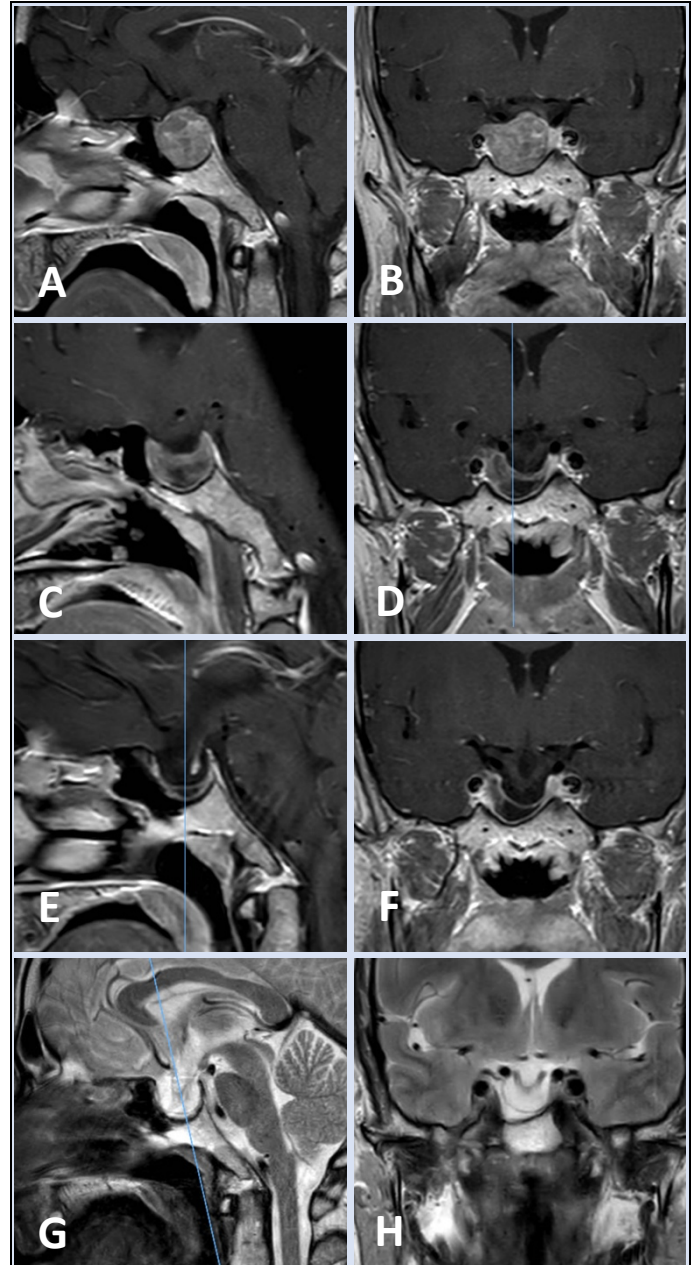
MRI of sellar region (sagittal and coronal): A and B, prior to medical management of prolactinoma; C and D, 8 months after the initiation of cabergoline treatment; E and F, 21 months after the initiation of cabergoline treatment; G and H, 4 years after the initiation of cabergoline treatment;
